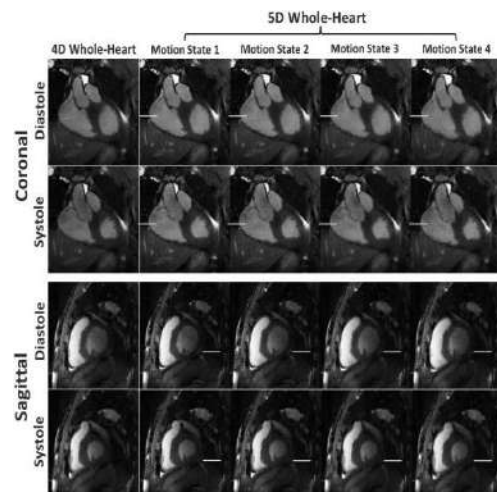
This is a 5D MRI of the heart. Observing the diastolic and systolic images on the top, Diastolic images have more grey color overall compared to the systolic images. This is an example of involuntary movement that can be picked up by MRI that can skew the overall image [1].
